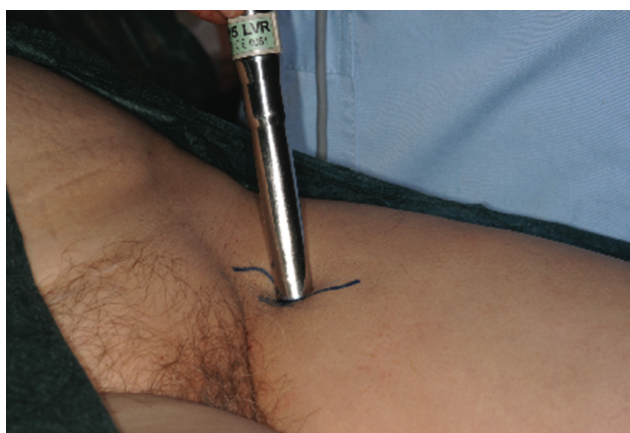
b: Preoperative lymphoscintigraphy for determination of the SLN.
